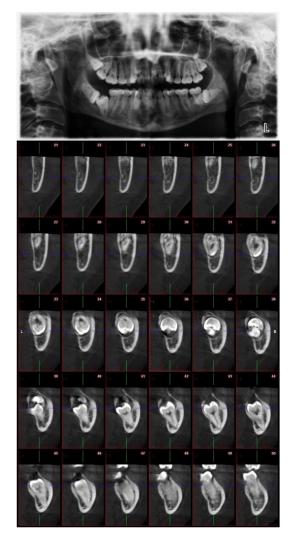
Orthopantomograph and CBCT of the patient revealing kissing molars and fibro-osseous lesion.
